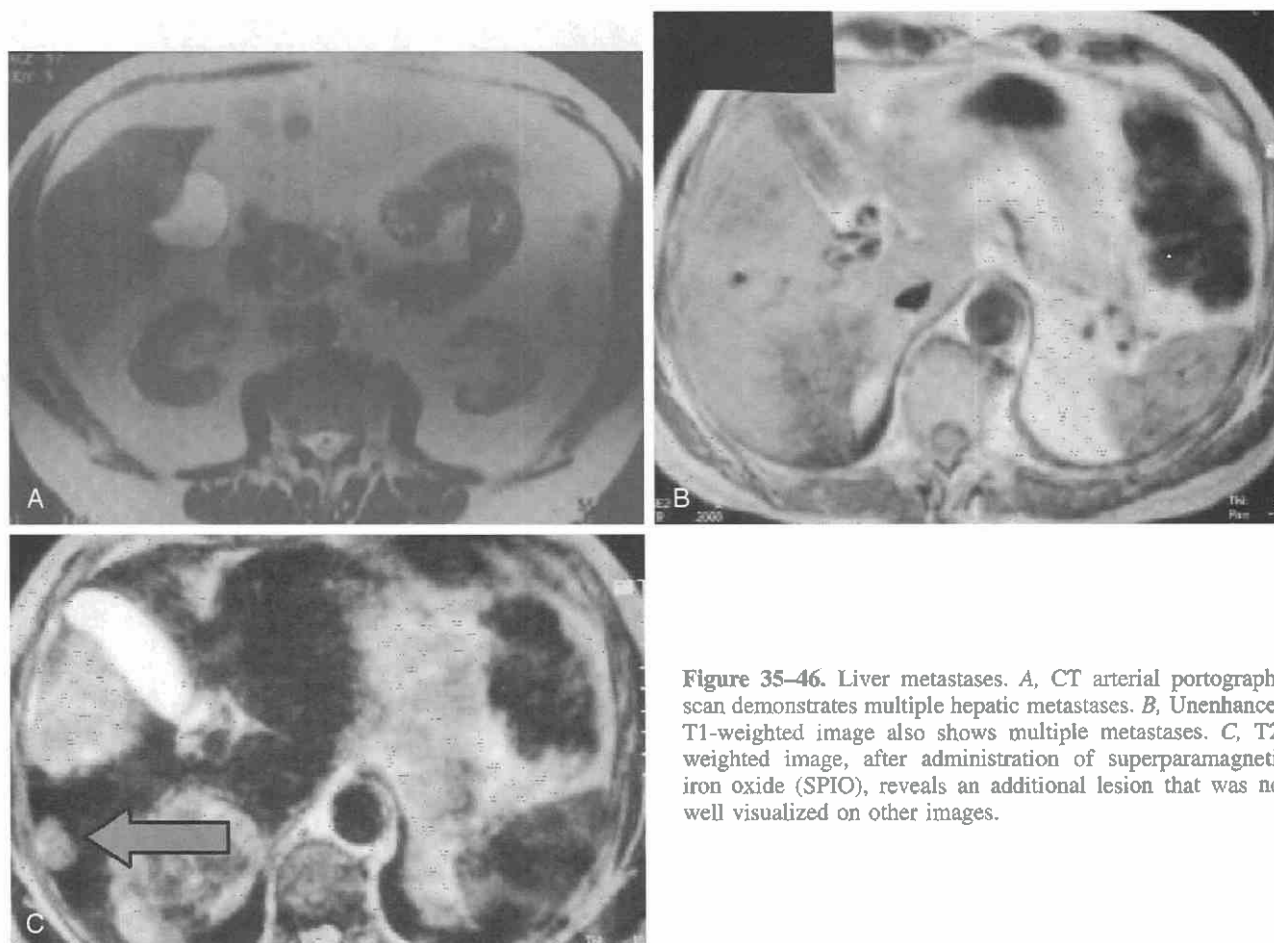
Liver metastases. *A*, CT arterial portography scan demonstrates multiple hepatic metastases. *B*, Unenhanced T1-weighted image also shows multiple metastases. *C*, T2-weighted image, after administration of superparamagnetic iron oxide (SPIO), reveals an additional lesion that was not well visualized on other images.
